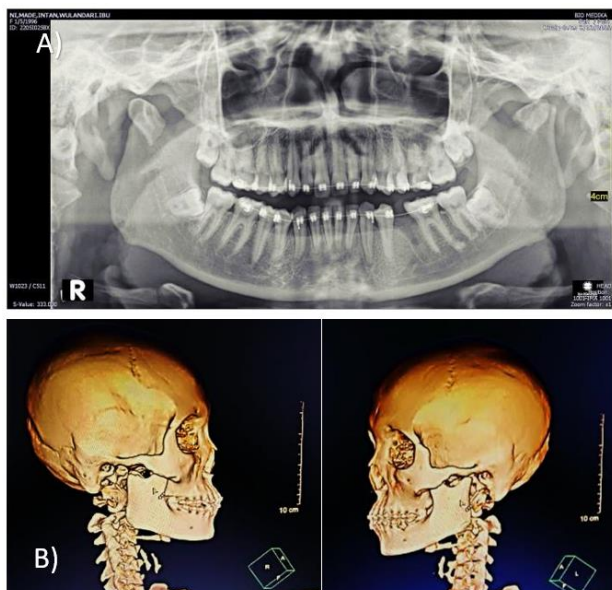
A) Radiographic imaging showing bilateral complete condylar fracture; B) CT imaging showing bilateral condylar fracture with inferomedial displacement.
